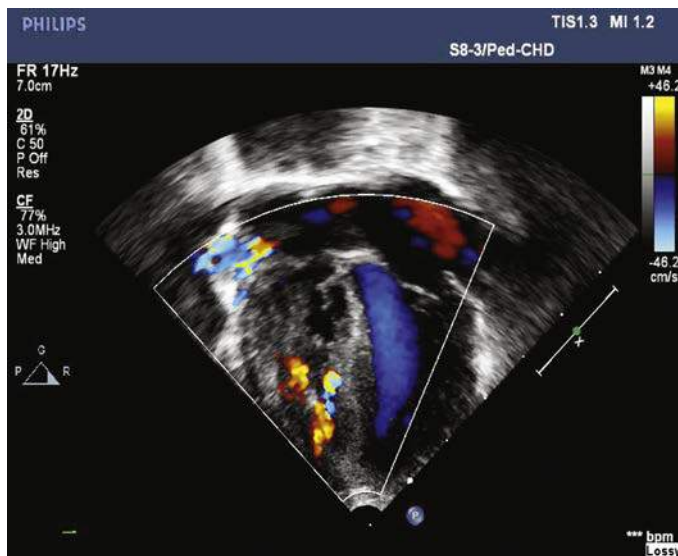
Echocardiogram in the four-chamber view with color Doppler imaging shows a hypoplastic right ventricle with several RV-to-coronary artery fistulae.
